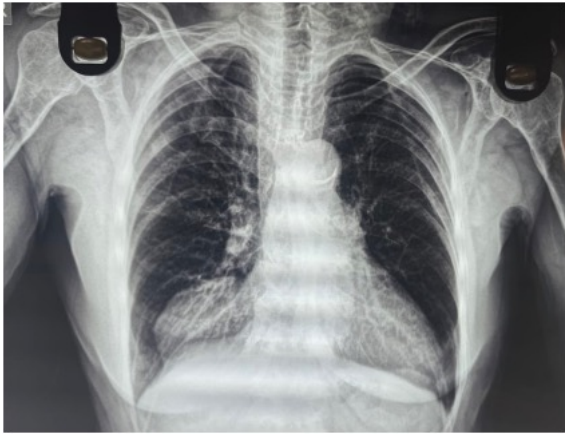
(a) Pre-op X-ray (b) Post-op X-ray (c) CT Chest showing right diaphragm with herniation of omentum
